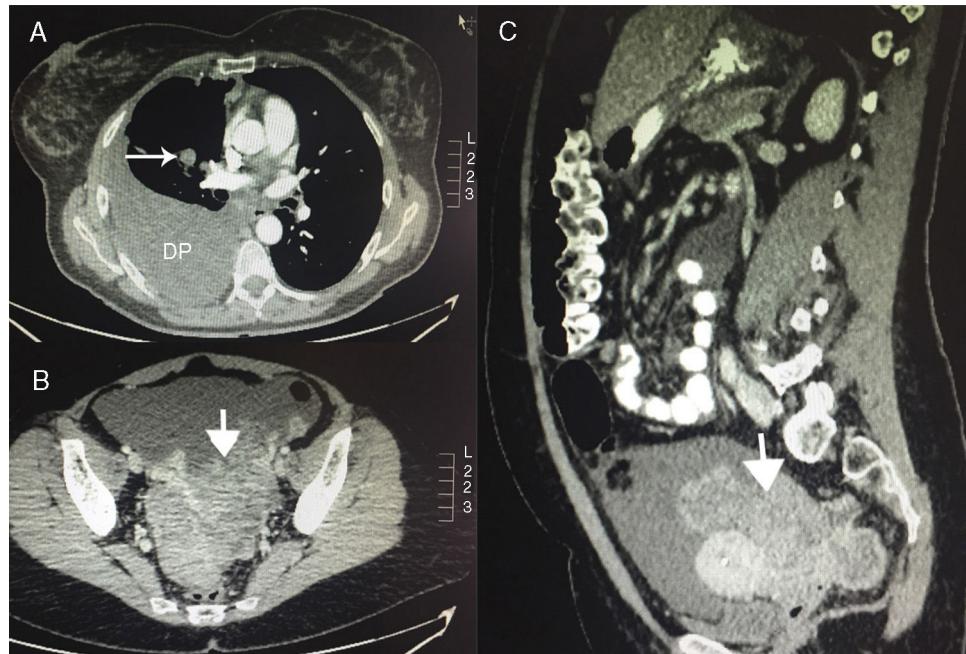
CT of Krukenberg tumor. (A) Axial CT slice from the chest showing right pleural effusion (PE) and right parahilar solitary pulmonary nodule. (B) Pelvic axial CT slice showing pelvic mass. (C) Sagittal CT slice showing pelvic mass.
